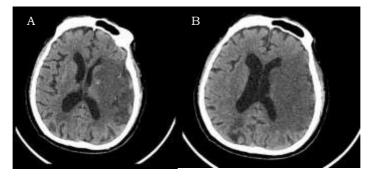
Non-contrast CT of a 79-year-old male revealed low ASPECTS affecting the distribution of left MCA.
